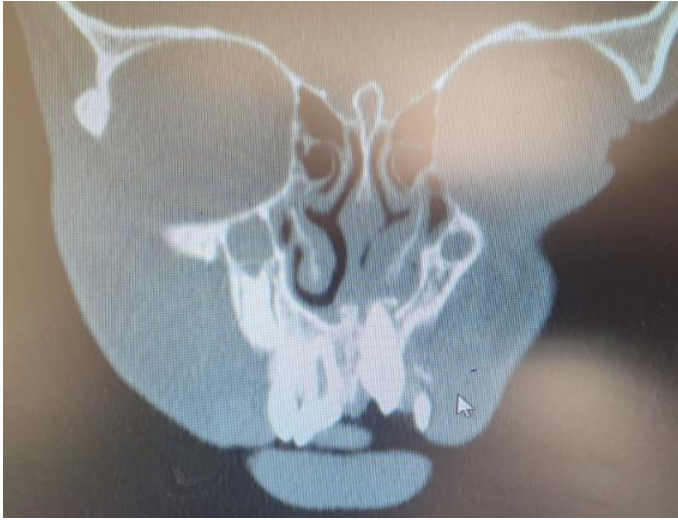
CT Coronal Image.
